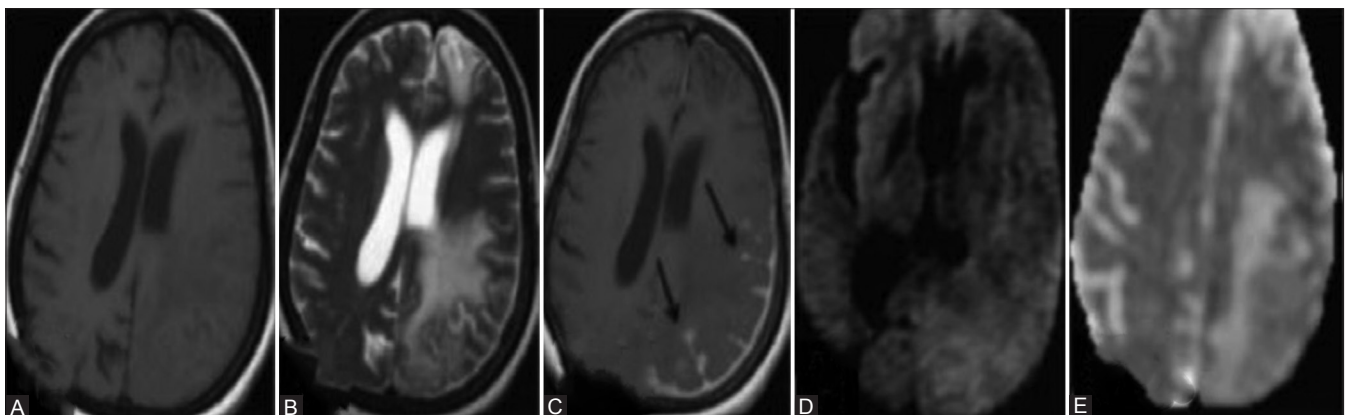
(A-E): History – A 47-year-old immunocompetent lady presented with headache for a period of 2 months, blurring of vision in left eye for 3 months, limb weakness with speech and memory disturbances for 2 months. MRI showed focal edema in the frontal and parietal white matter on left side on T1 W (A) and T2 W (B) images. There was mixed pachymeningeal, leptomenigeal enhancement (arrows) in left parietal region on post-contrast study (C) with restricted diffusion noted on diffusion weighted and apparent diffusion coefficient images (D and E)
